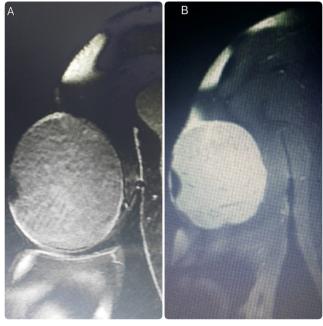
The lesion had low signal intensity on T1-weighted images (a), T2weighted images; its signals were hyper intense relative to the muscle (b).
